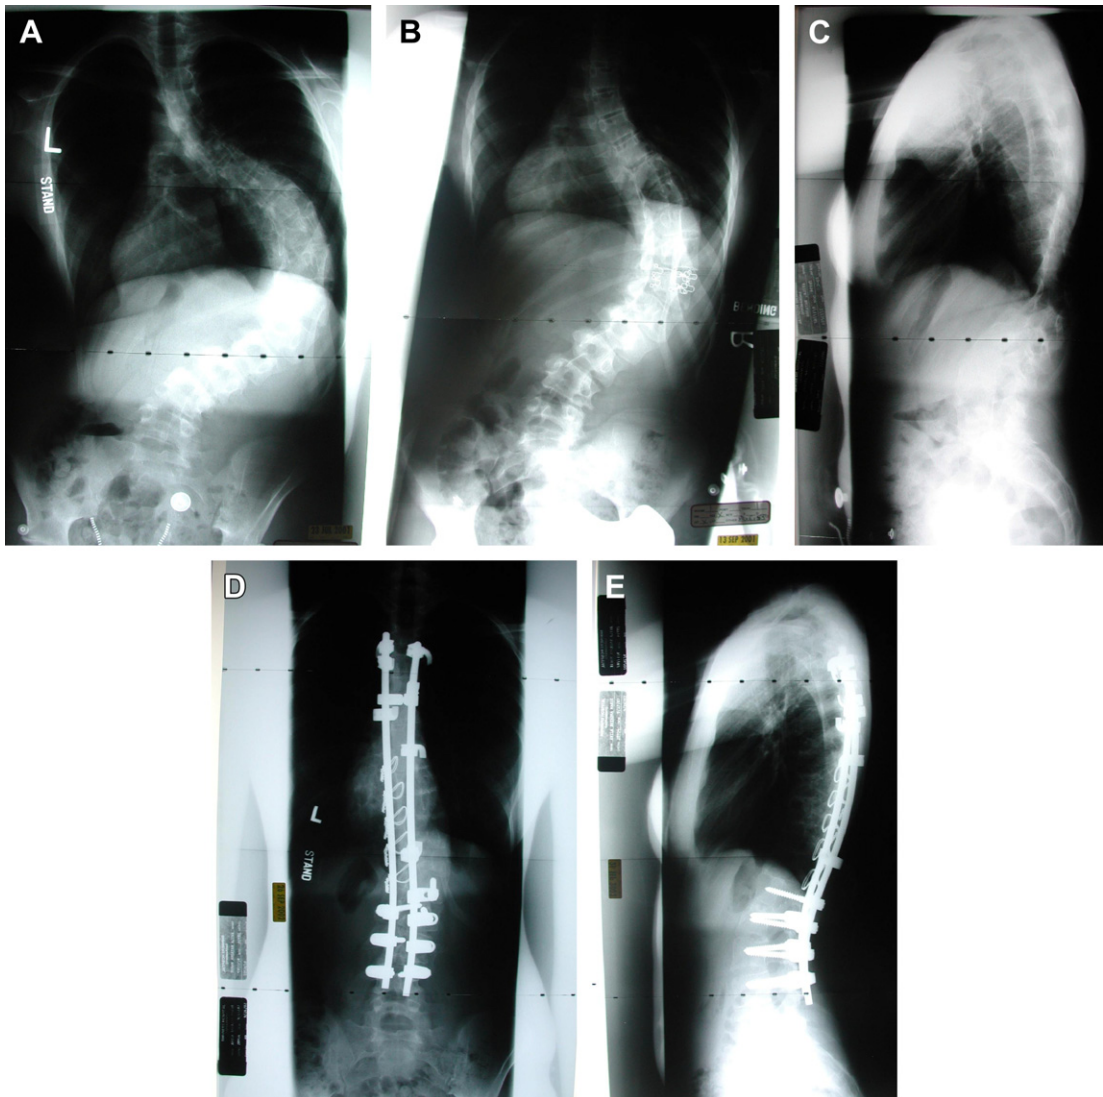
(A) Large round rigid adolescent idiopathic scoliosis. (B) The curve is rigid on bending radiographs. (C) Preoperative lateral radiographs. (D) Postoperative correction obtained by anterior release, wide posterior release, and spinal instrumentation. (E) Postoperative lateral radiograph.
